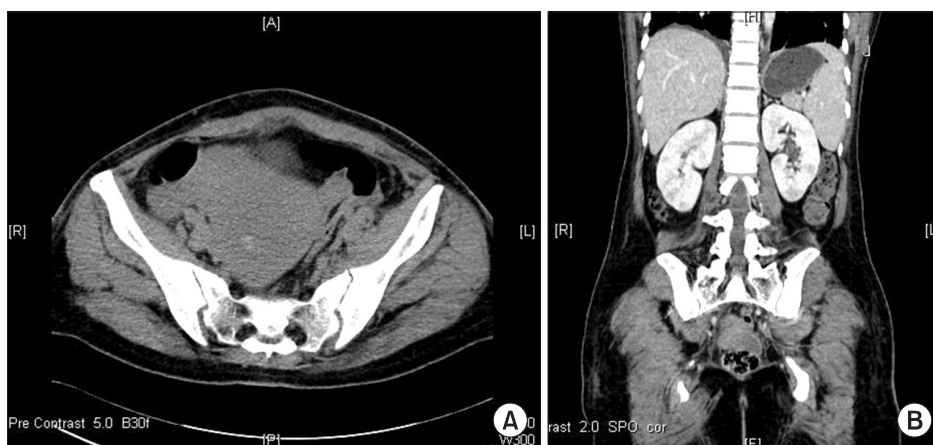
(A) Coronal view of abdomen and pelvis CT at admission was normal. (B) Sagittal view of abdomen and pelvis CT at admission was normal.
